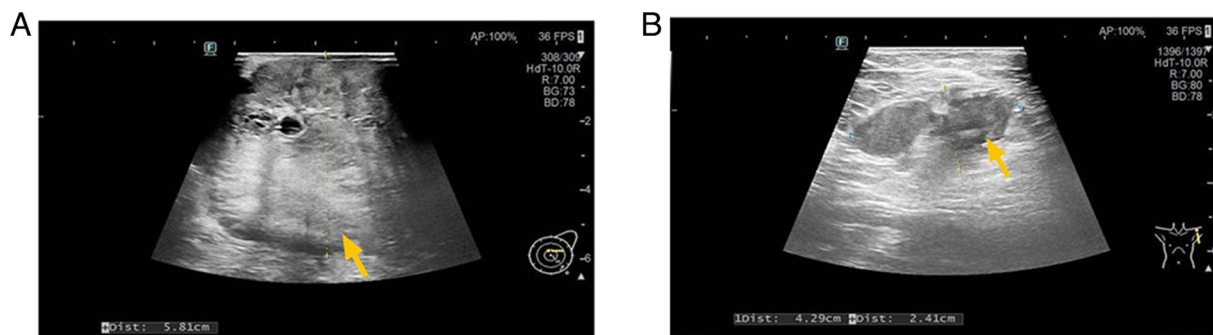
Pre-treatment Ultrasonograms from June 2023. (A) Ultrasonogram of the left breast mass (yellow arrow). (B) Ultrasonogram of the left axillary lymph nodes (yellow arrow).
